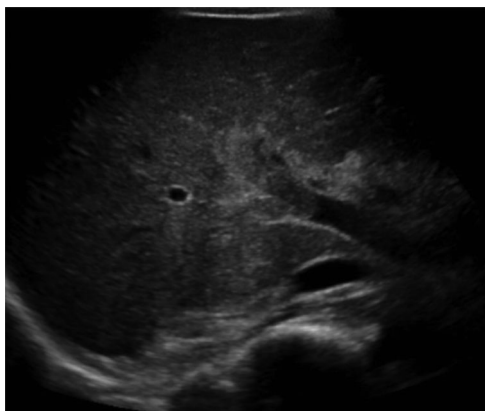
Filling defect in the portal vein on ultrasound.
